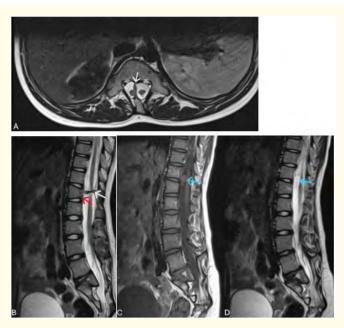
MRI findings showing type II diastematomyelia and a dorsal neurenteric cyst. (A) Axial T2-weighted image demonstrating two symmetrical hemicords separated by a bony spur extending from the D12 to L3 vertebra, consistent with type II diastematomyelia (White arrow). (B) Sagittal T2-weighted image showing diastematomyelia (white arrow) with mild compression of the D12 vertebral body (Red arrow). (C) Sagittal T1-weighted image showing a bilobed intradural-extramedullary cyst at the D11-D12 level with isointense signal relative to the spinal cord, consistent with a neurenteric cyst. (D) Sagittal T2-weighted image showing the same bilobed cyst with hyperintense signal, clearly delineated from the surrounding cord (Blue arrow).
